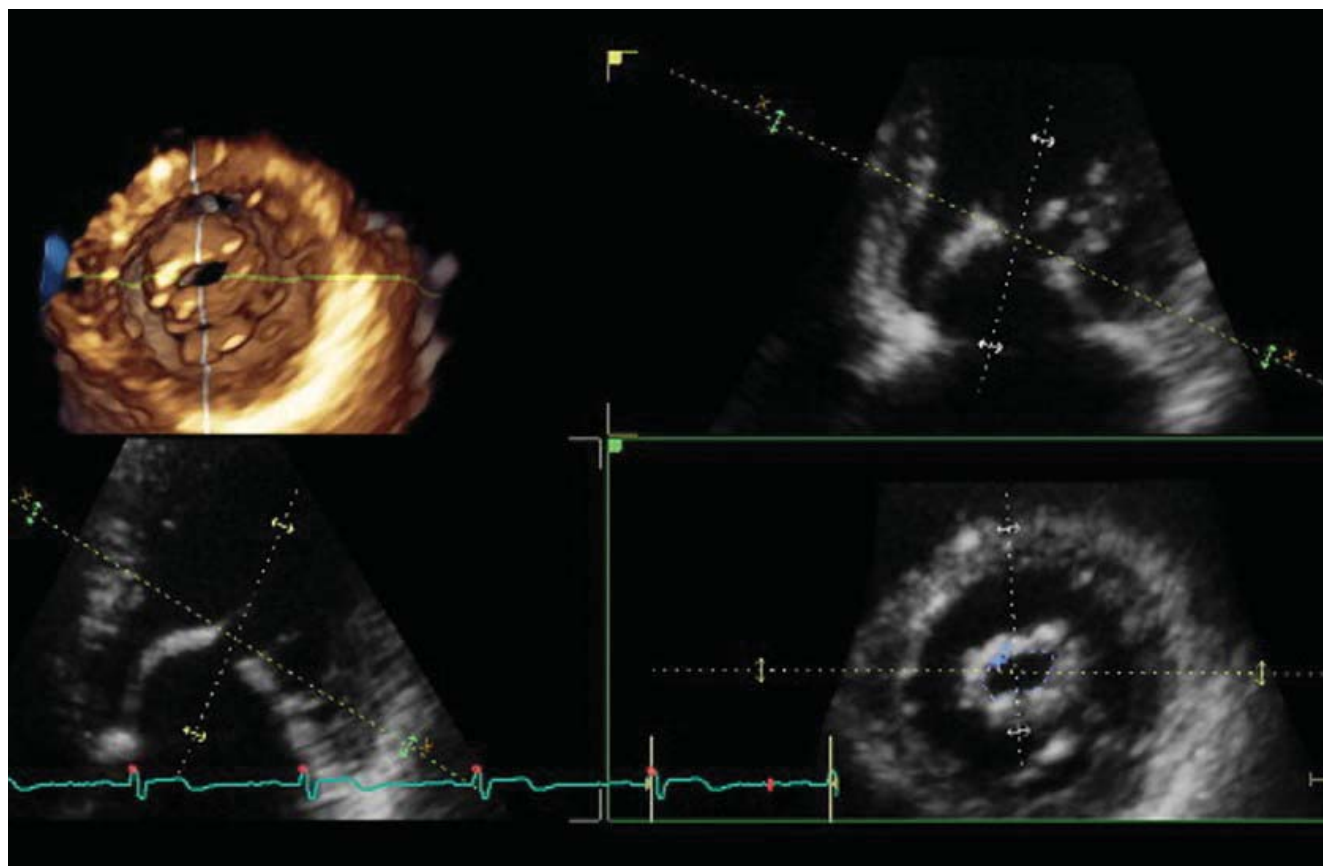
Transthoracic three-dimensional quantitation of rheumatic mitral stenosis severity. The cut plane of the three-dimensional dataset (green dotted line) is perpendicular to the opening direction of the mitral valve orifice, at the tip of mitral leaflets level, allowing an accurate planimetry of the smallest residual opening orifice.
